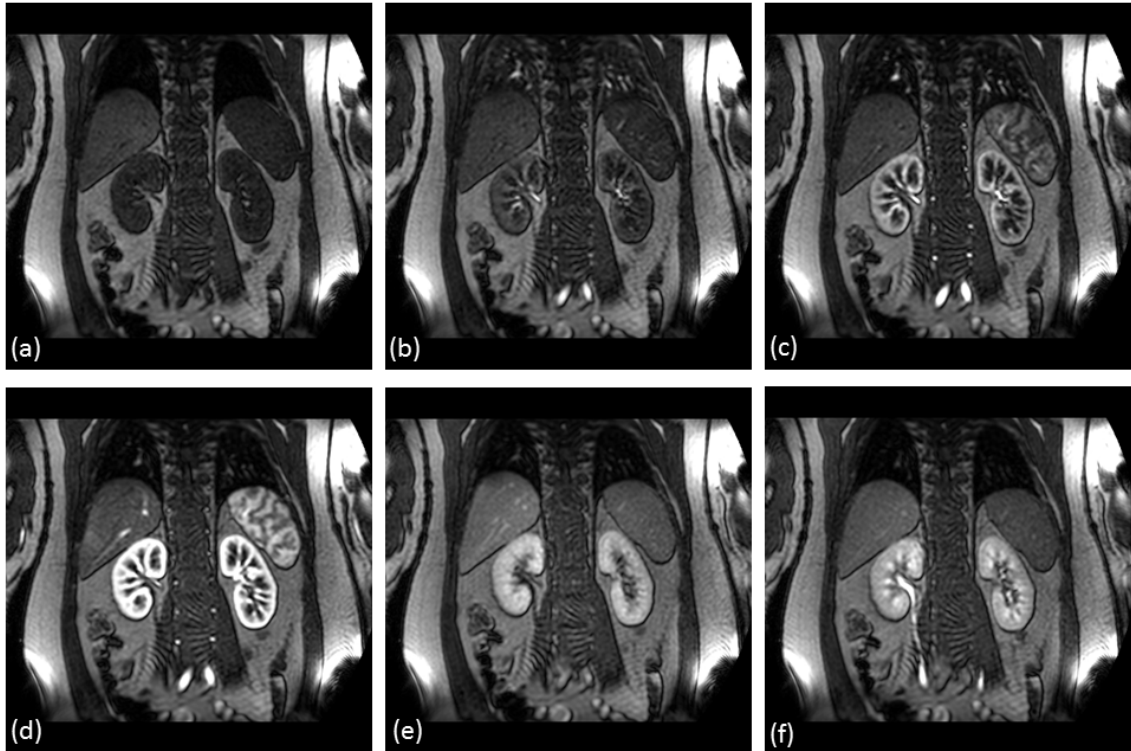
Example of DCE-MRI renal data acquired in the coronal plane. (a) pre-contrast image, (b)-(d) bolus arrival and contrast agent uptake, (e)-(f) post-contrast washout phase.
